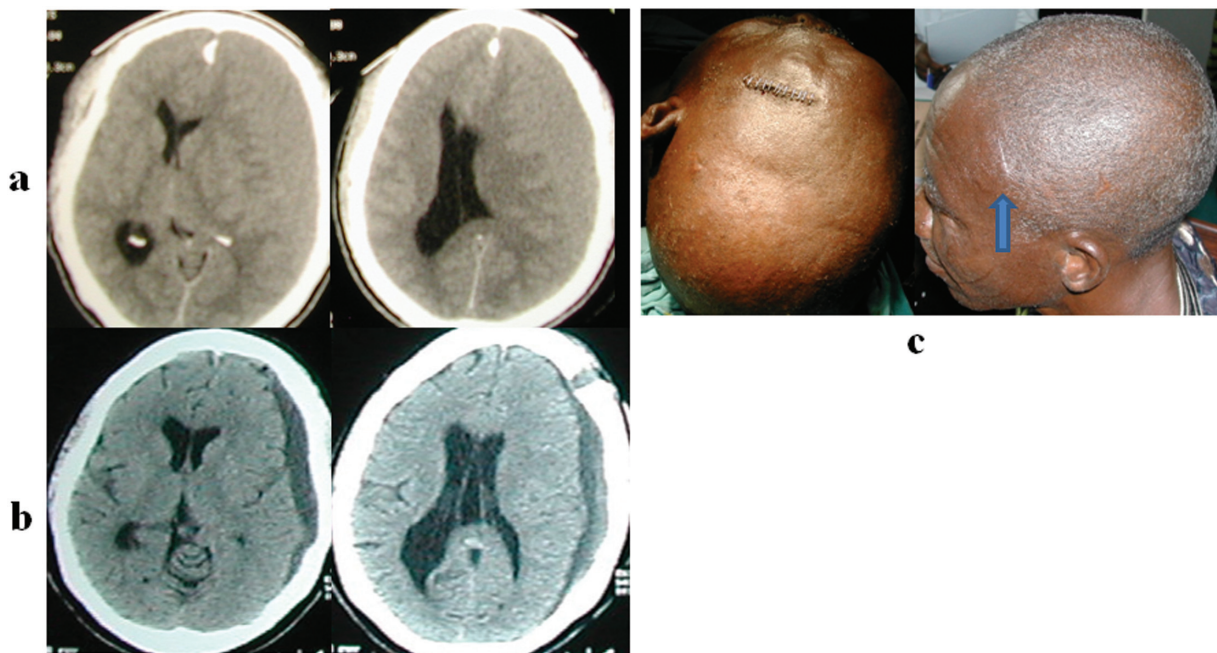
An elderly man presented unconscious and had cranial CT scan (a) showing left-sided subacute subdural hematoma with marked mass effect; (b) cranial CT 5 days post-surgical evacuation via the left anterior-frontal single burr hole showing marked early postoperative resolution of the intracranial hypertension. The residual subdural collection is a well-diluted hygroma essentially. There is no pneumocephalus (c) surgical incision immediately postoperatively (left figure) and on the first clinic visit 4 weeks postoperatively (arrow, right figure).
